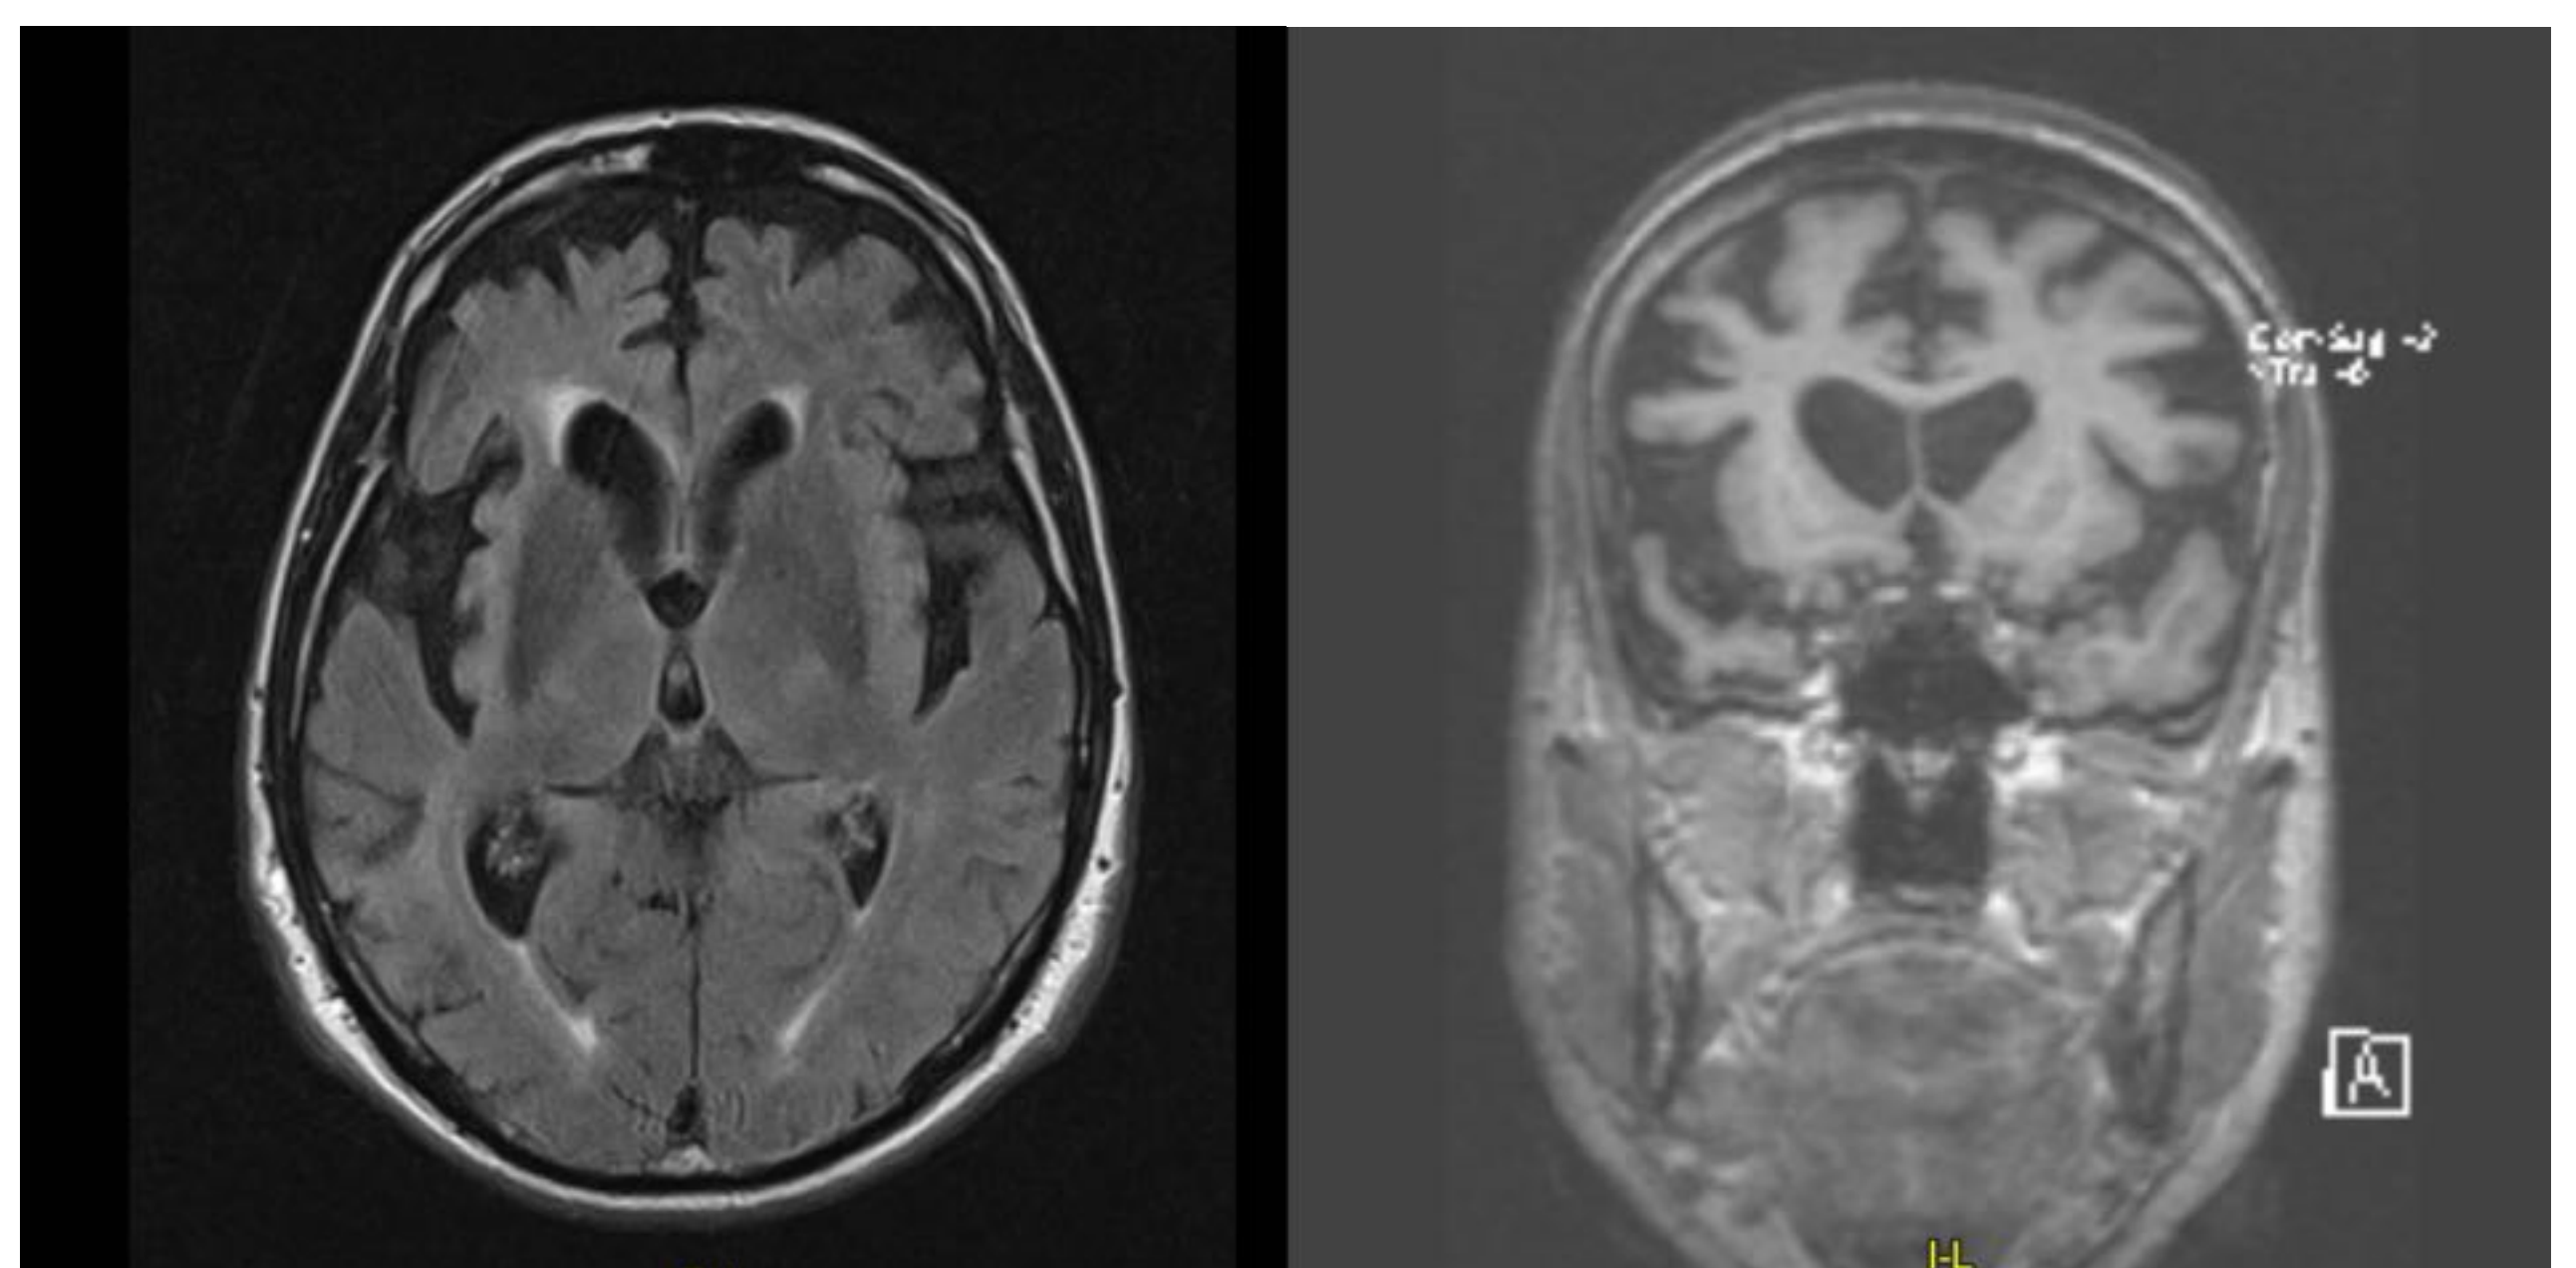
MRI showing cortical fronto-temporal atrophy (right>left) in Axial FLAIR and Coronal T1 sequences
